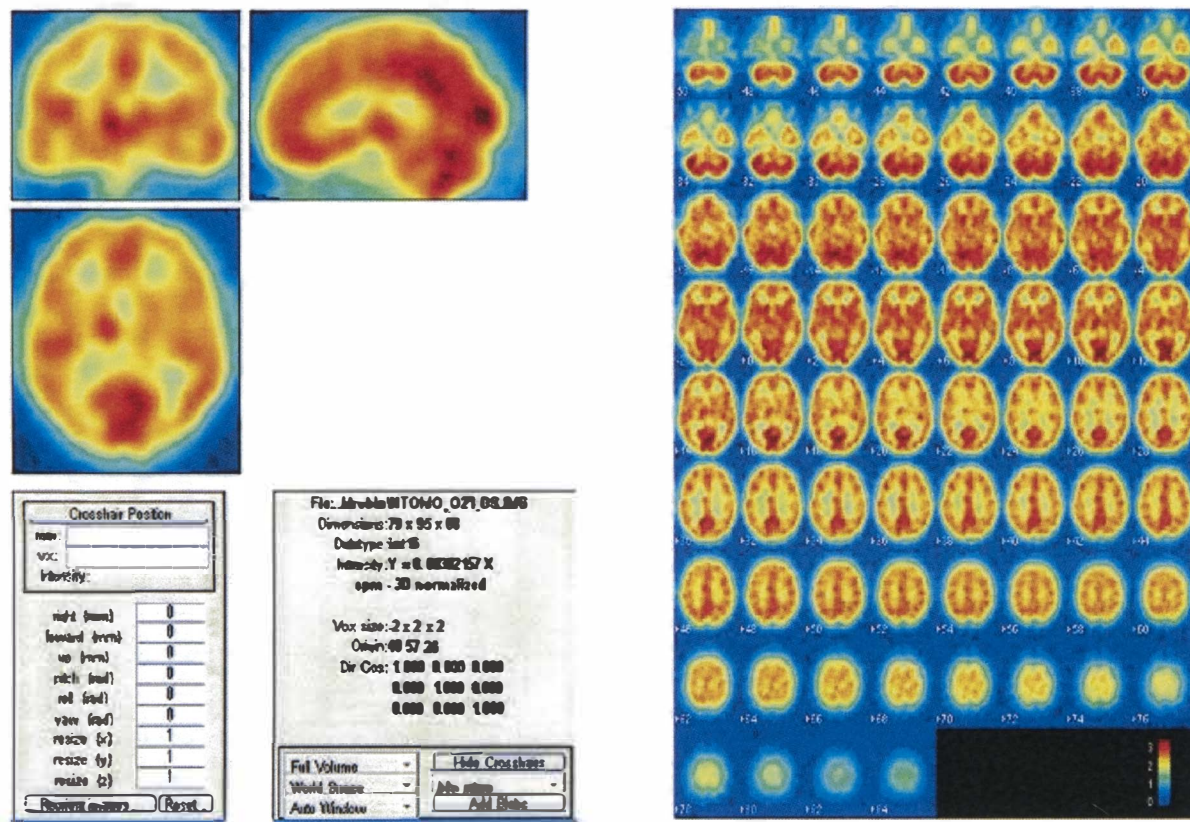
The SPECT brain image and the SPECT 2D image for the various slices from the bottom of the brain (the first top slice) to the top of the brain (the last slice)
